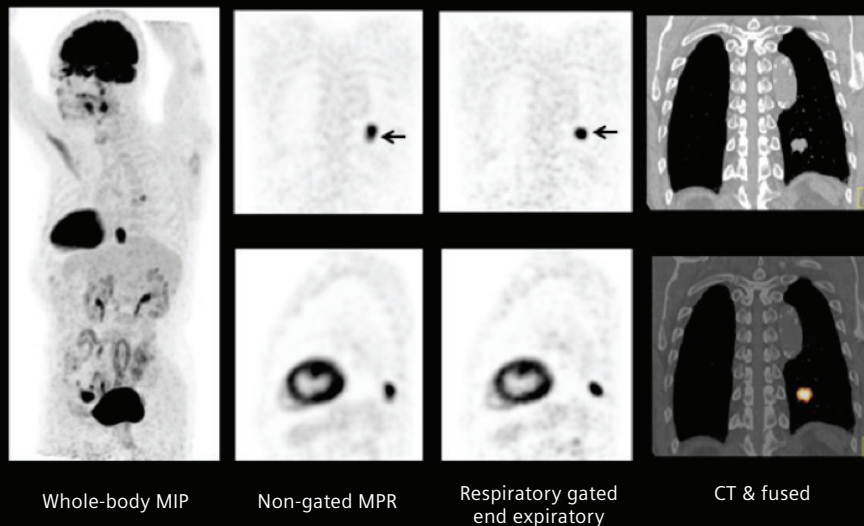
Large solitary lung nodule with high ^{18}F FDG uptake showing respiratory motion-related blurring on non-gated standard PET acquisition. Respiratory gated end expiratory images obtained using an optimal gating approach show smaller nodular size with sharp margins due to elimination of respiratory motion-related blurring. The CT shows irregular spiculated margin of the lung nodule which is suggestive of malignancy. Fusion images show high ^{18}F FDG uptake within the large irregular lung nodule which strongly indicated presence of malignancy. SUV_{max} was 11.5.
